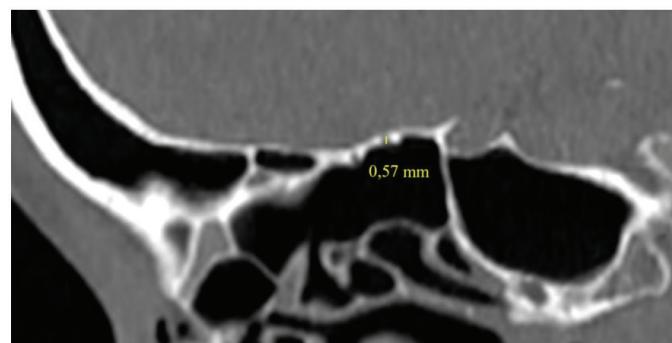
Posterior ethmoidal artery diameter on a CT scan of patient Pham Thi V. Source: Dang Vuong Kiet, 2023.
